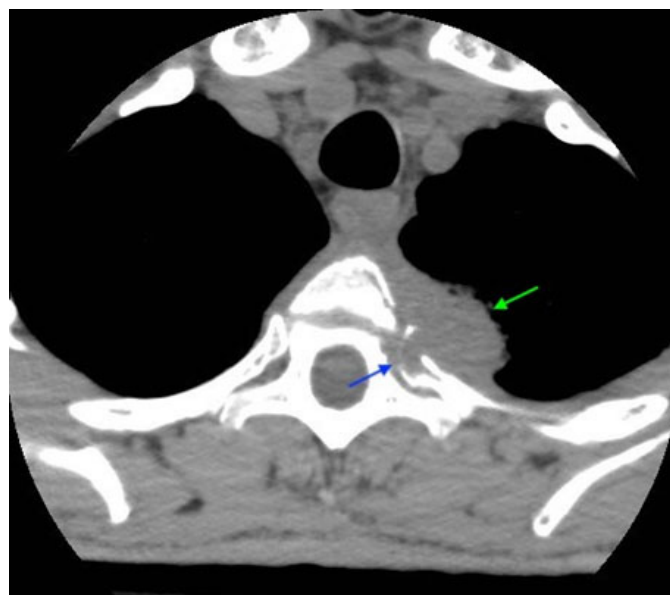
Axial computed tomography scan without contrast. Lytic destruction of left fourth rib (blue arrow) can be seen with adjacent mass-like consolidation (green arrow) in apical segment of left lung.
